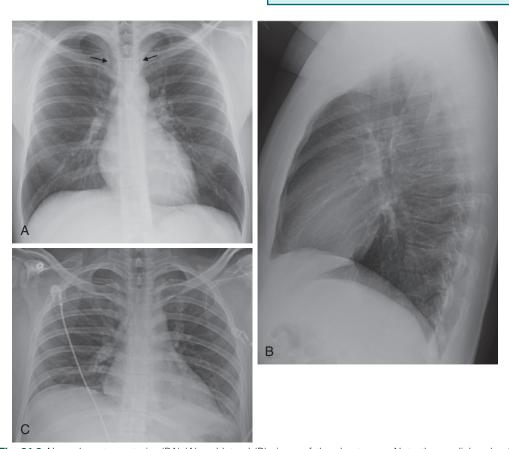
Normal posteroanterior (PA) (A) and lateral (B) views of the chest x-ray. Note the medial ends of the clavicles (arrows) with the spinous process (arrows) framed between them (A). A subsequent follow-up anteroposterior (AP) (C) x-ray obtained shortly after the PA radiograph shows that the cardiac silhouette appears larger, due to magnification from the AP technique.
